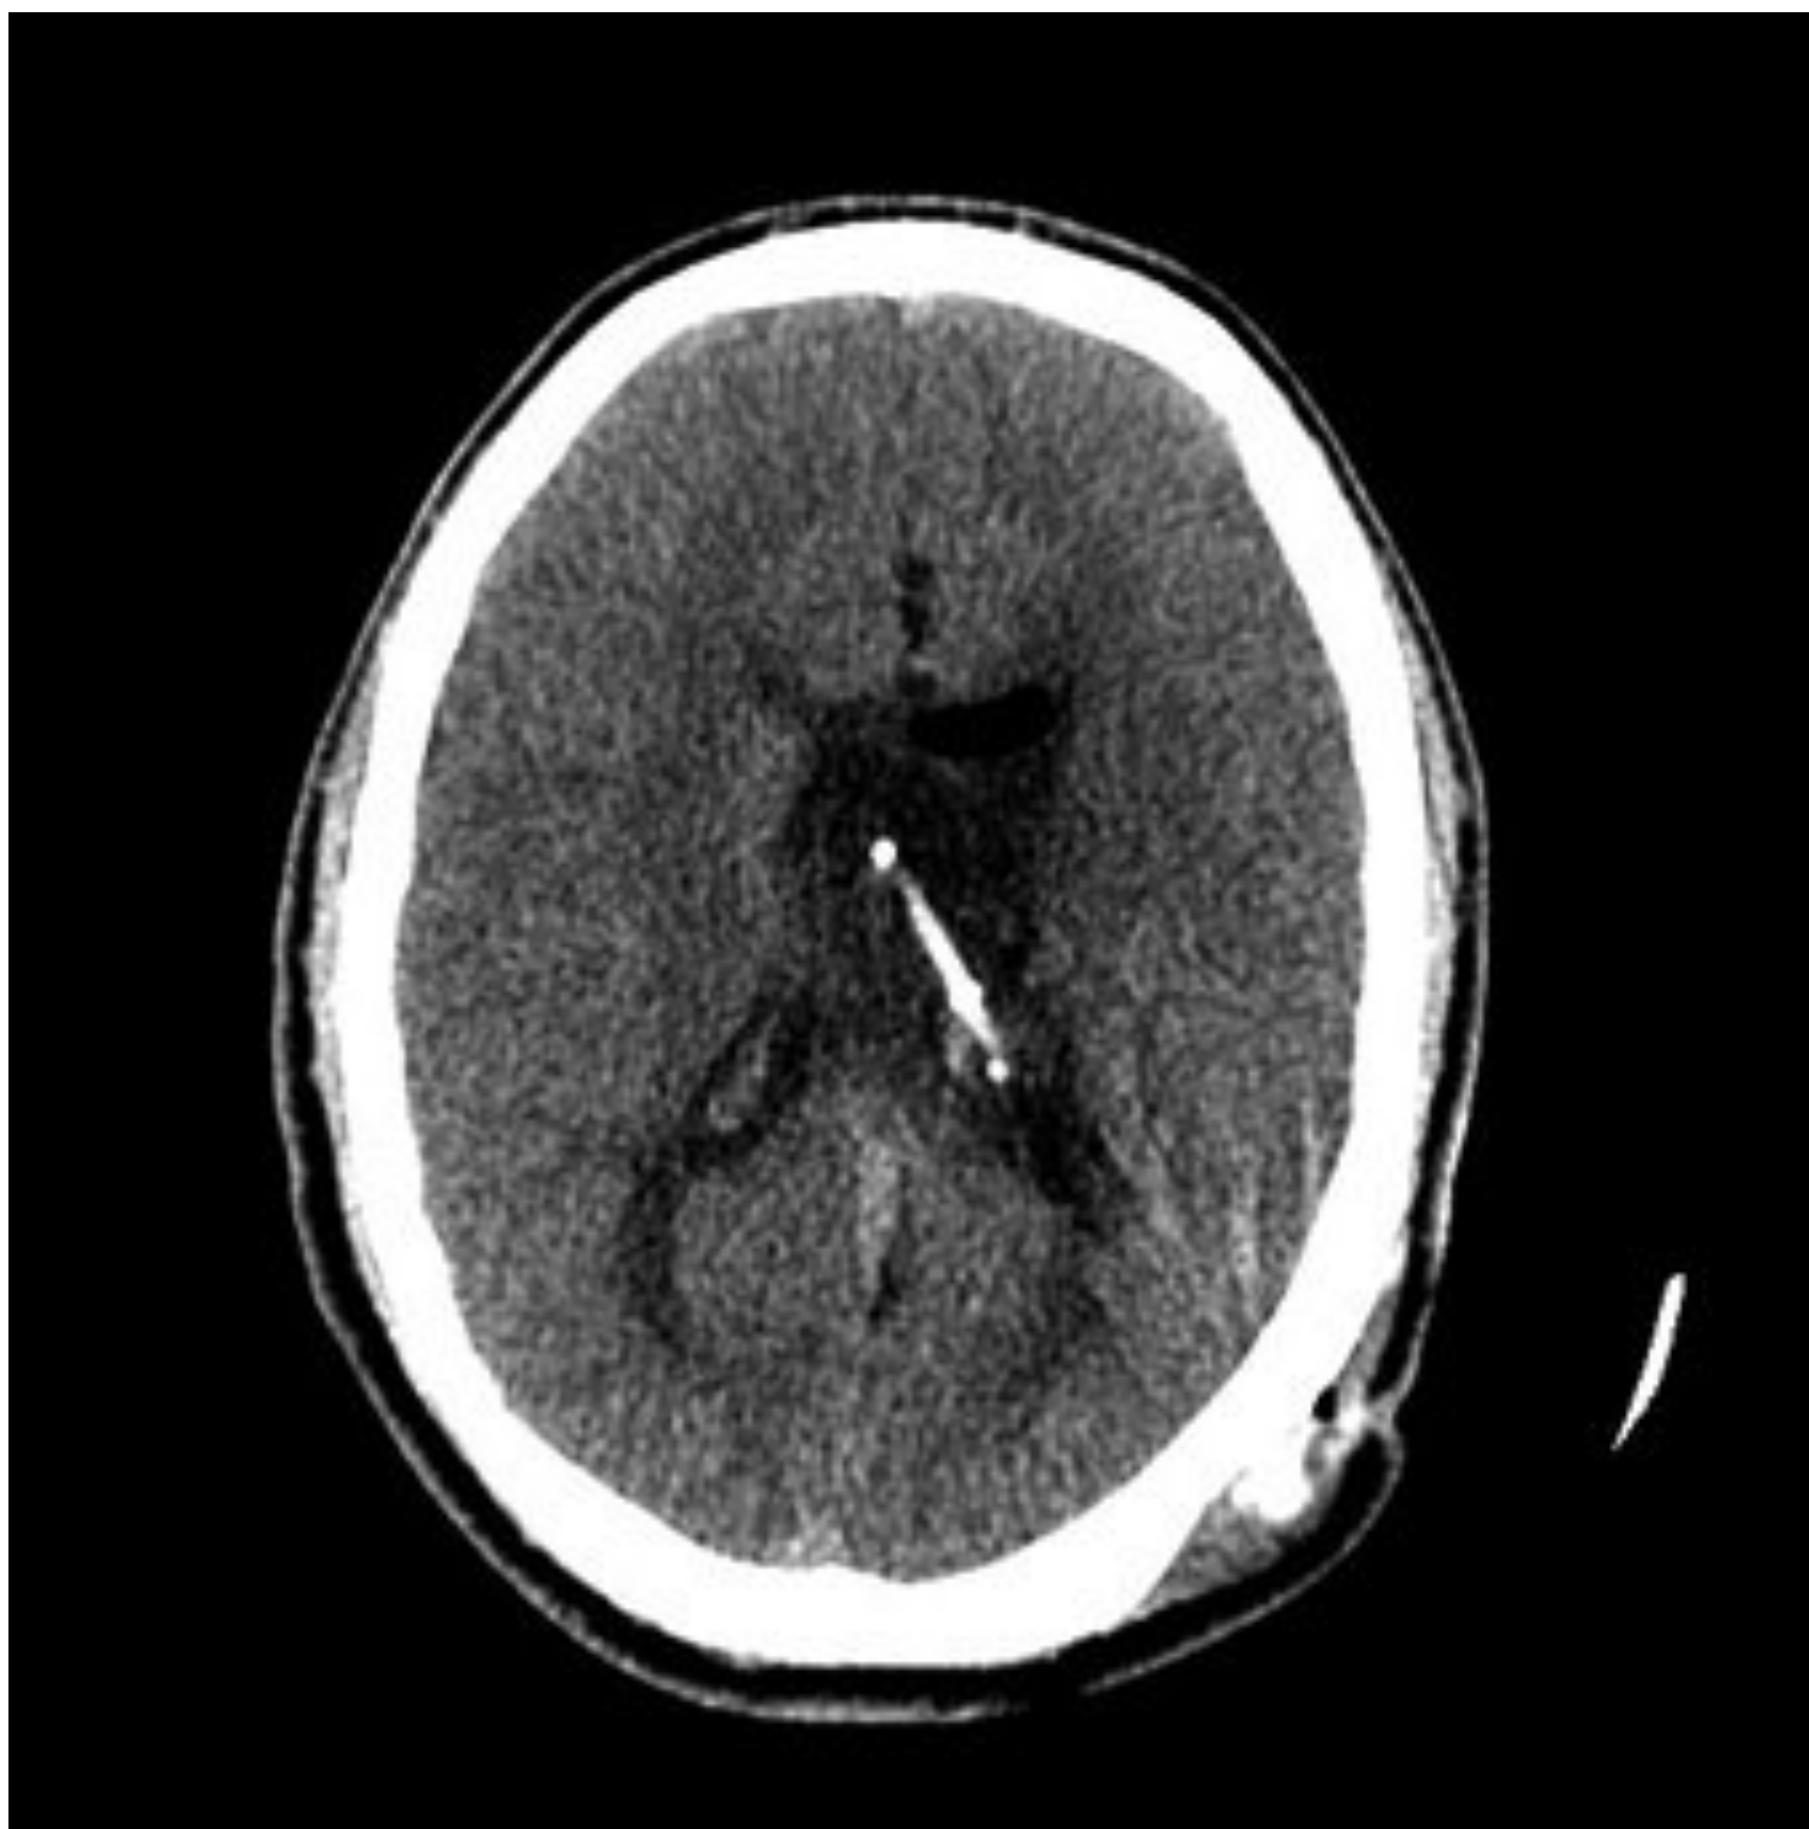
Postoperative CT scan of same patient depicted in Fig. 21.2 after shunt revision.
